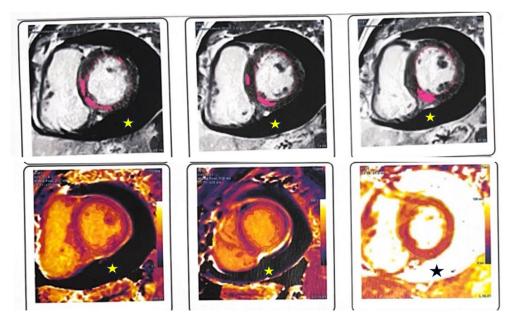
c.7. Cardiac MRI in presented case showing exudative pericarditis with large amount of fluid (star), without thickening of the pericardial sheets and nonischemic scarring (probably postmyocarditis) in the LGE sequences, in the anterolateral, inferolateral and inferior walls of the basal and medioventricular LV.
